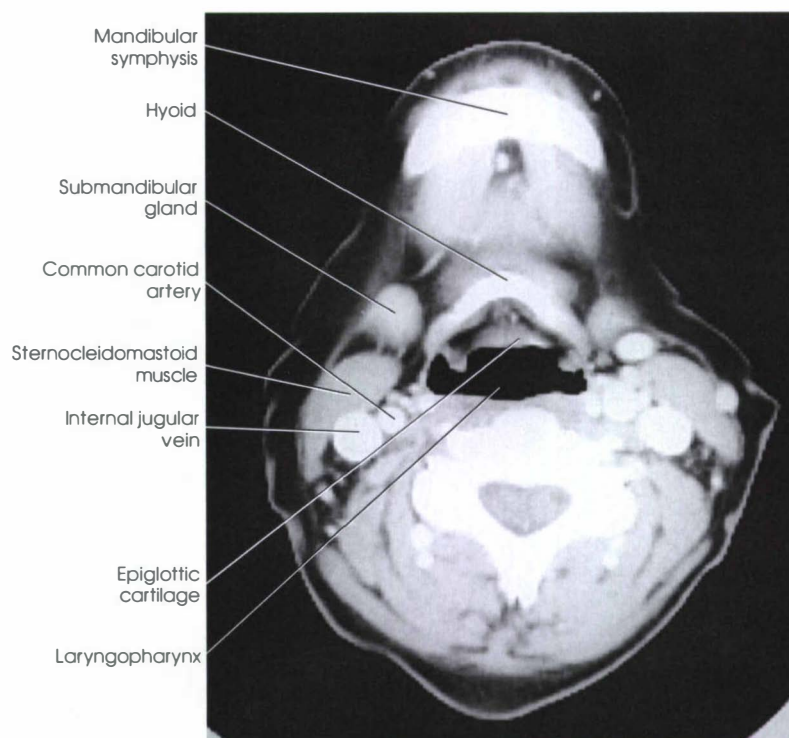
CT image through the C4 corresponding to Fig. 27-9.
